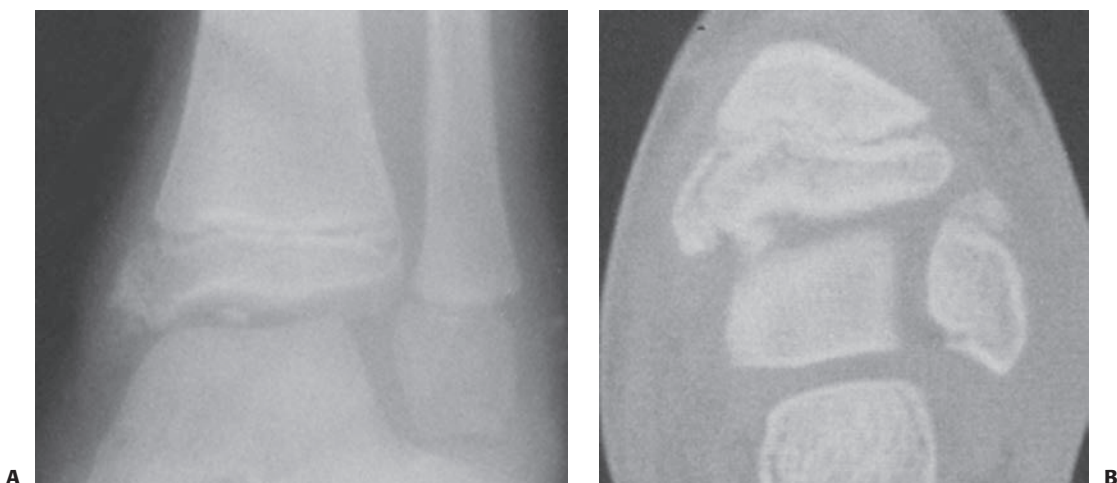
A: Salter–Harris type III fracture of the medial malleolus and Salter–Harris type I fracture of the fibula in a 9-year-old girl. An intra-articular fragment was visible only on a mortise view radiograph. B: CT scan outlined the Salter–Harris type III fracture of the medial malleolus and the fragment of bone.
